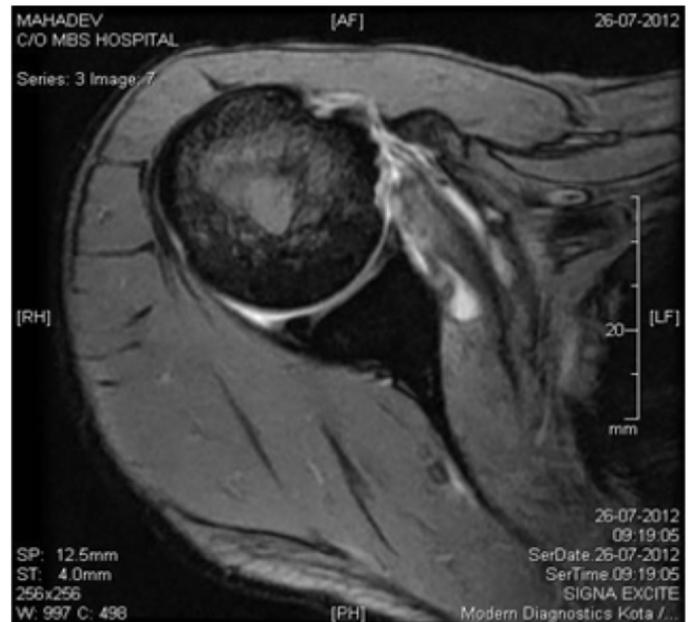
MRI T2 GRE axial image showing osteophyte formation at coracoids process with subcoracoid impingement and full thickness tear of subscapularis tendon.
